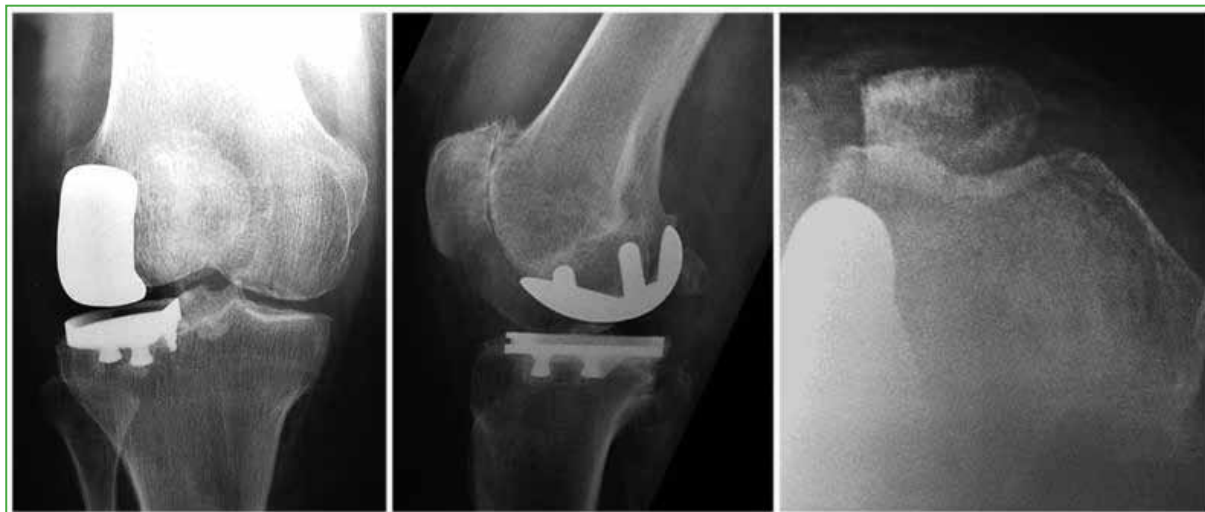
Postoperative right knee radiographs. Correct alignment of the prosthesis and external patellar facetectomy.
